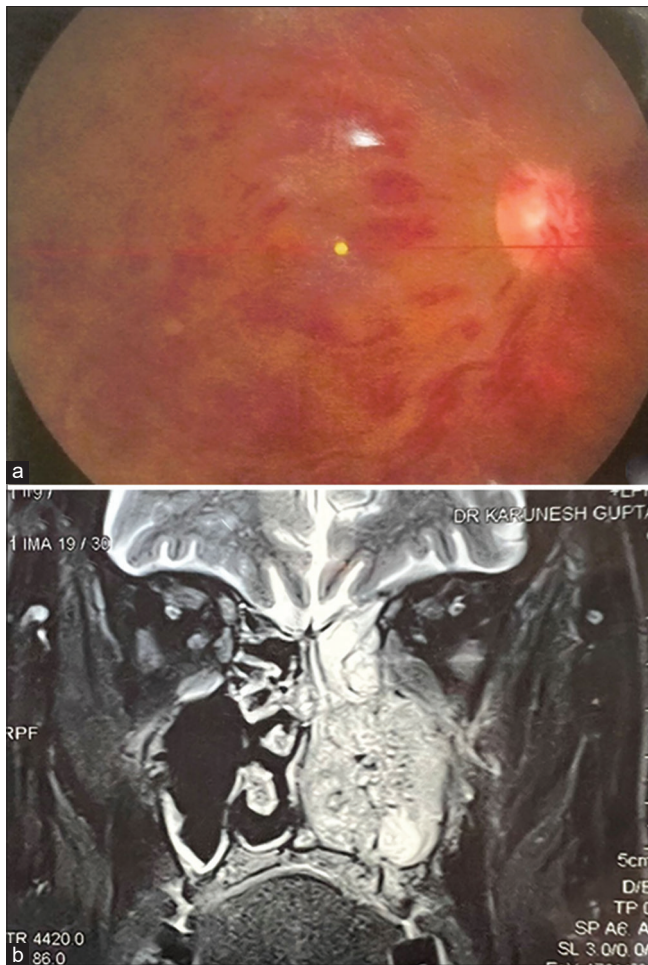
(a) Fundus picture showing central retinal vein occlusion in the right eye; (b) Contrast-enhanced magnetic resonance imaging (coronal section) revealed left pansinusitis; erosion of sinus walls with enhancing inflammatory soft tissue in the left medial extraconal space
